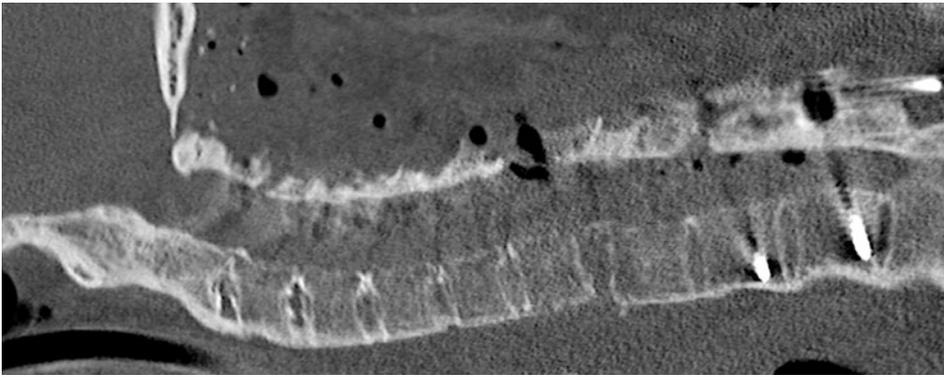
CT scan on admission to primary hospital after the trauma. The CT scan shows an anteriorly displaced, luxated cervical fracture C7/T1: B3 according to AOSpine subaxial cervical spine injury classification fracture [1].
